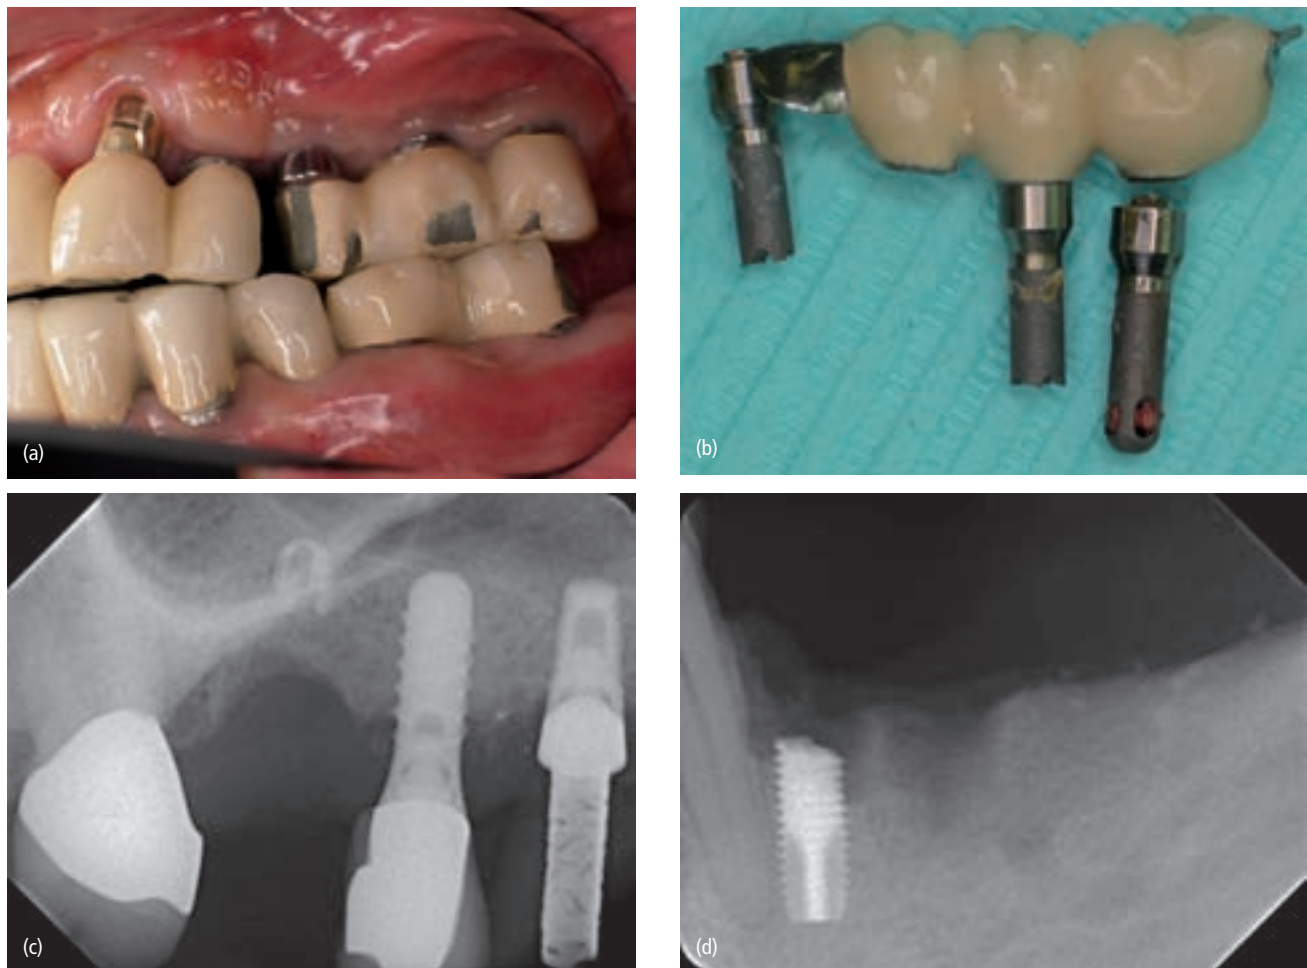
(a) Implant-supported porcelain crown fractures due to parafunctional habits; (b) occlusal stress causing implant body fracture; (c, d) radiographs of fractured implants.
